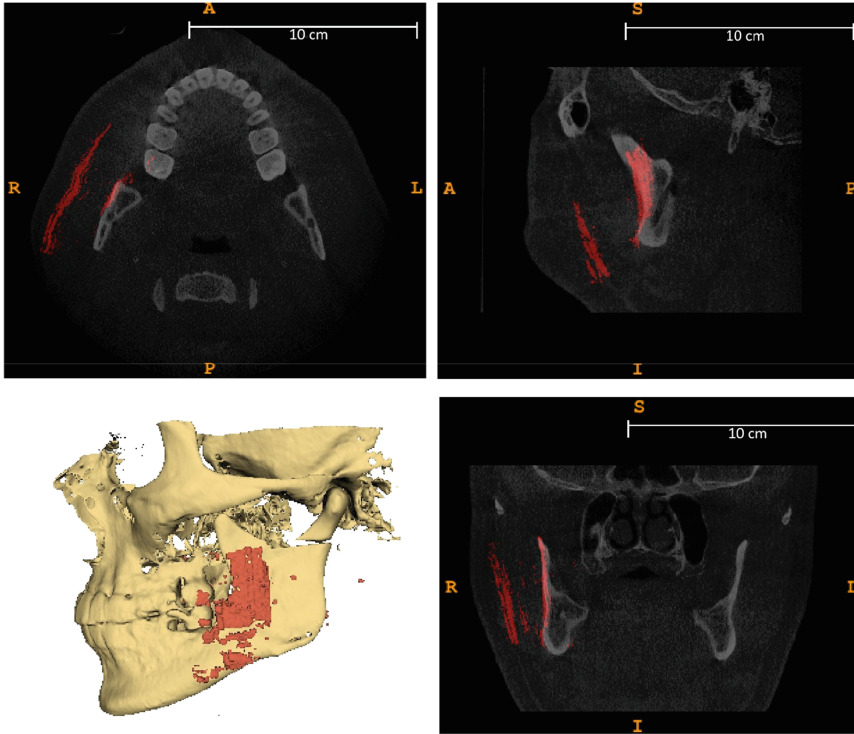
Coronal view of CBCT (grayscale) and 3D ultrasound (red semitransparent) volume overlay. Areas of high ultrasound reflection depicted in red. Both the masseter muscle and the mandibular ramus surface area can be clearly visualized in both modalities. In slice cross-sections, deeper layers of skin are visible in the ultrasound scan (red semitransparent). The surface layers of skin were removed during US acquisition by 2D image cropping (Color figure online).
